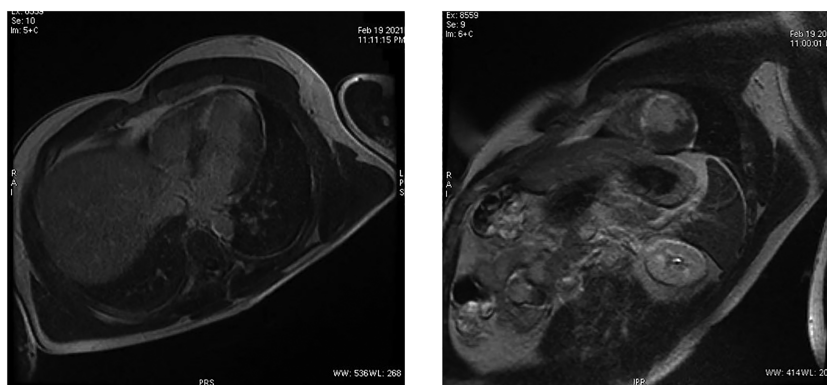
Magnetic resonance imaging images. Late gadolinium enhancement in left ventricular anteroapical, septoapical, midseptal, and basal–septal segments.
